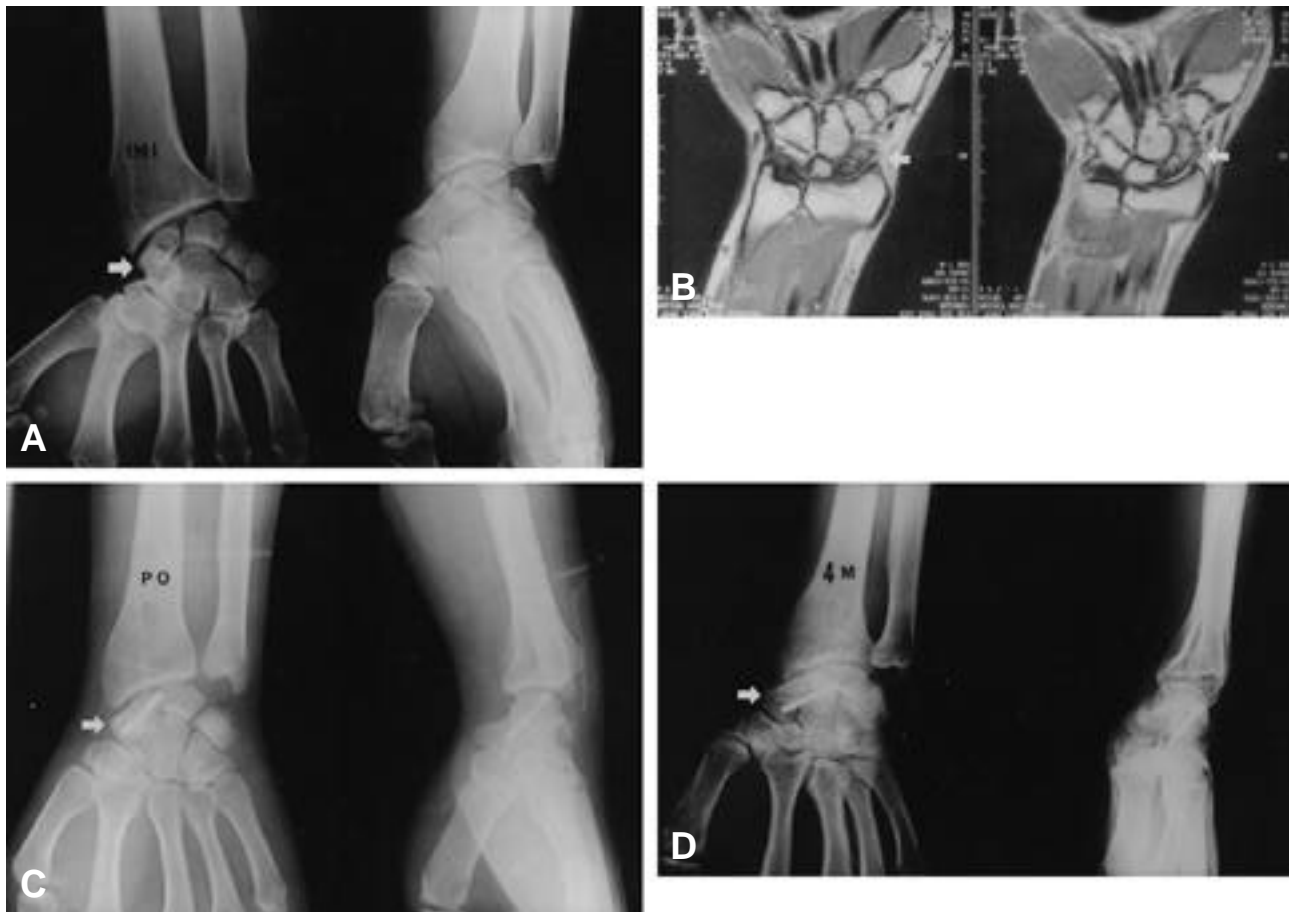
A. Plain radiograph shows a radiolucent lesion with sclerotic and cystic changes of proximal pole of scaphoid. B. T2 image of MRI shows decreased signal intensity of scaphoid and inhomogenous, high-signal cystic lesions in the proximal pole of scaphoid. C. After retrograde fixation of proximal pole nonunion fragment with Herbert screw and autogenous bone graft. D. 20 Weeks after retrograde fixation of proximal pole nonunion fragment with Herbert screw and autogenous bone graft, plain radiograph shows radiologic union.
